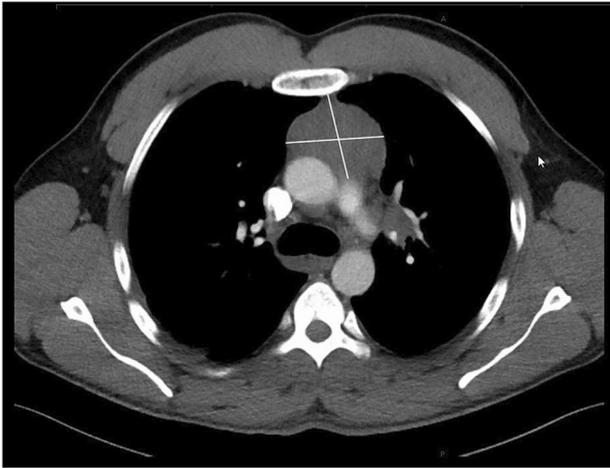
Axial image from the CT scan taken at diagnosis showing the largest diameter of the mediastinal myeloid sarcoma.
